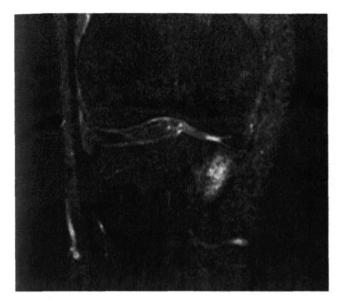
A T2-weighted image of a very large medial tibial BML.
